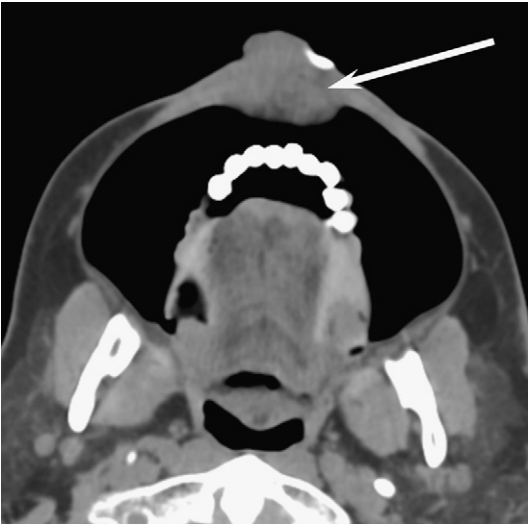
Puffed-cheek technique. Axial CT image of a patient with squamous cell carcinoma of the lower lip demonstrates the lesion (*arrow*) surrounded by air instead of adjacent to the jaw. Buccal and gingival lesions may be difficult to distinguish and characterize without this technique. Furthermore, bone invasion can be confidently excluded.
